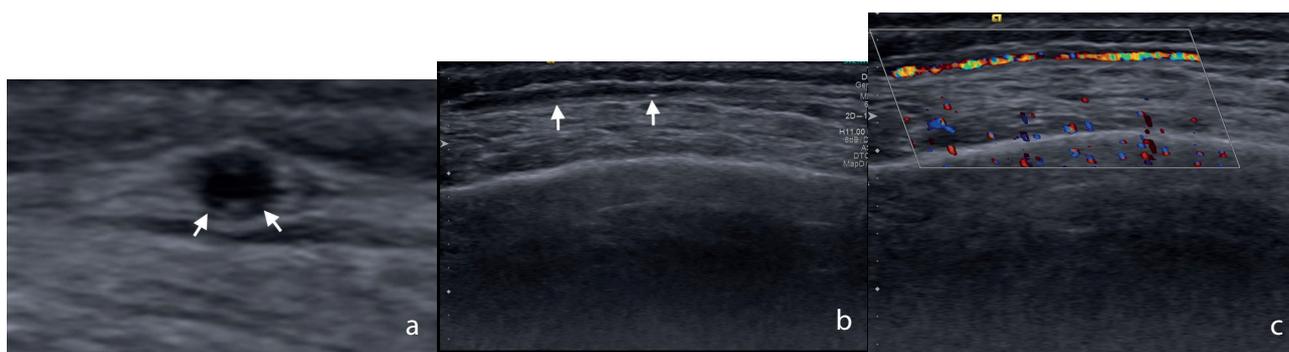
(a) Transverse view of gray-scale US image demonstrates halo sign which is concentric wall thickening of the temporal artery with hypoechoic appearance (arrows). (b) A longitudinal view of the gray-scale US image reveals wall thickening and luminal narrowing (arrows) in the temporal artery. (c) Color flow Doppler US shows an aliasing artifact representing the temporal artery's turbulent flow.
